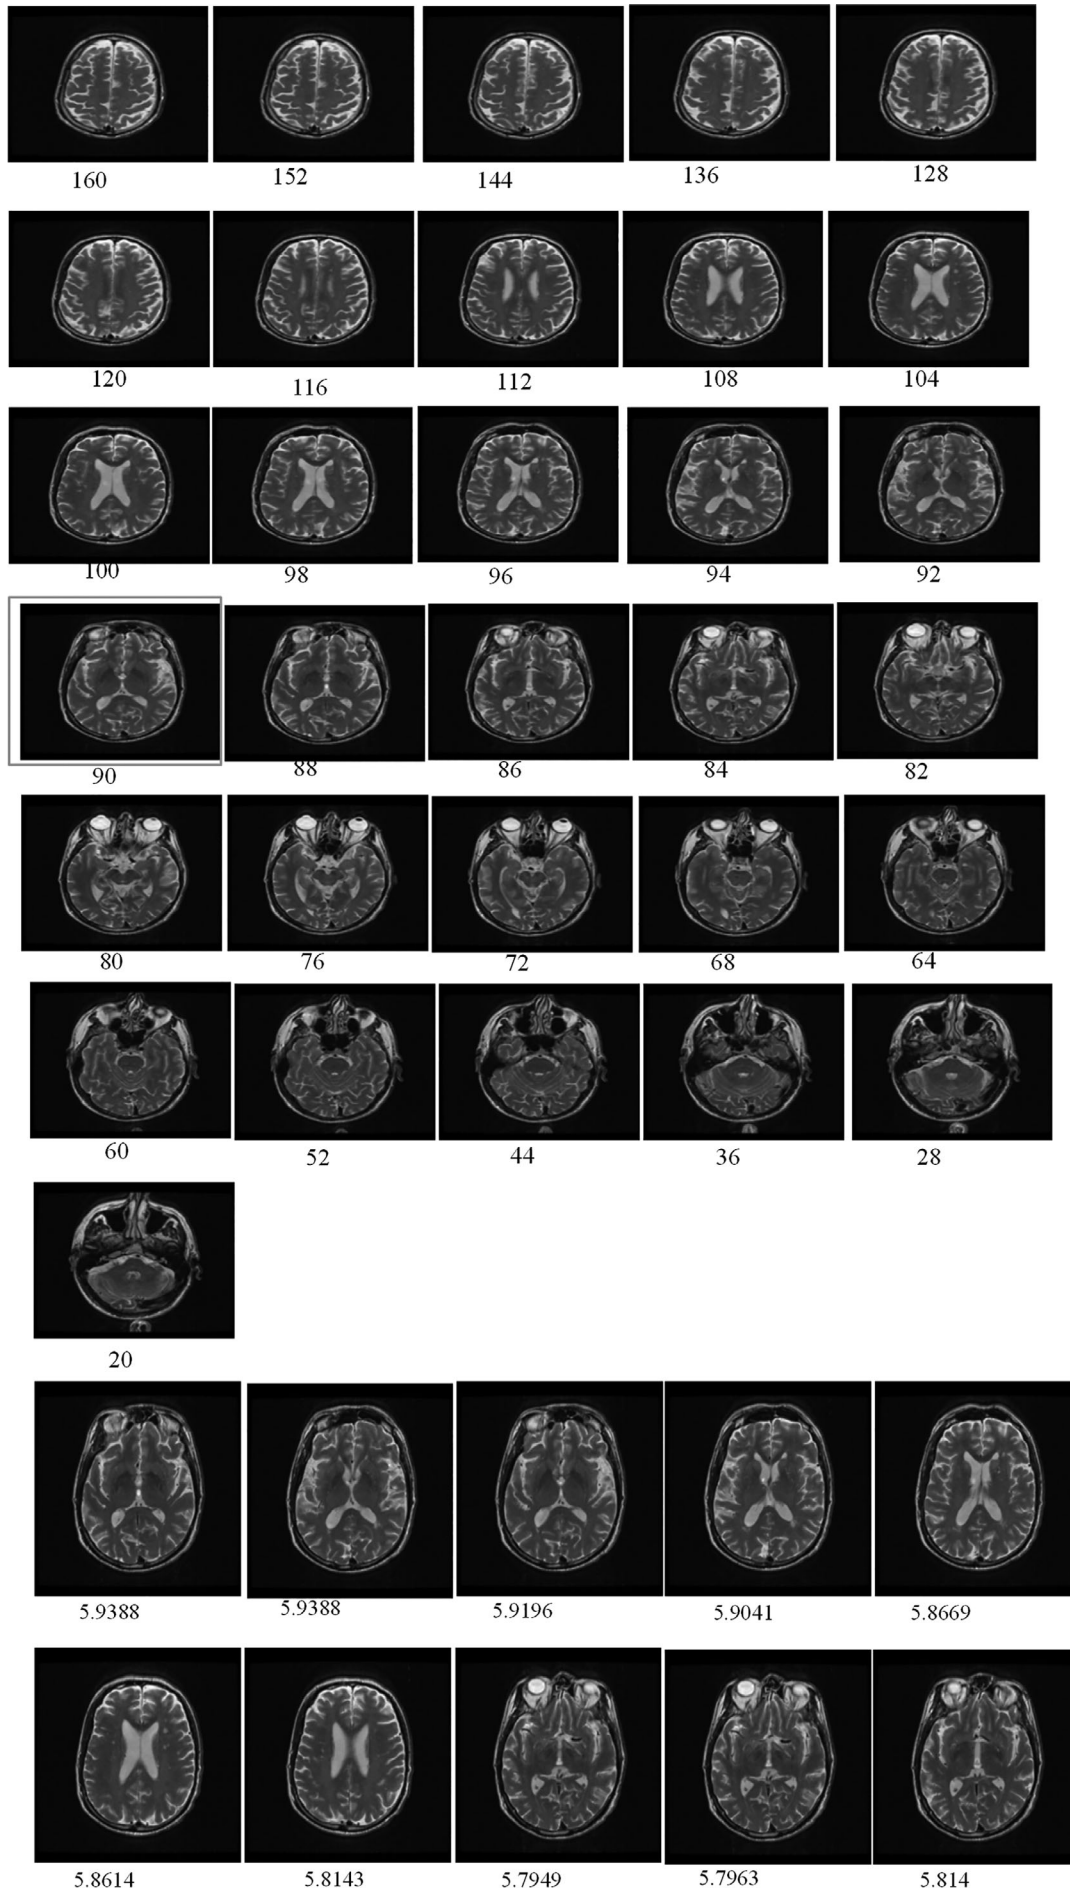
Selected Slices from a MRI 3(A) slices selected at first phase of algorithm, 3(B) Top images having high entropy
